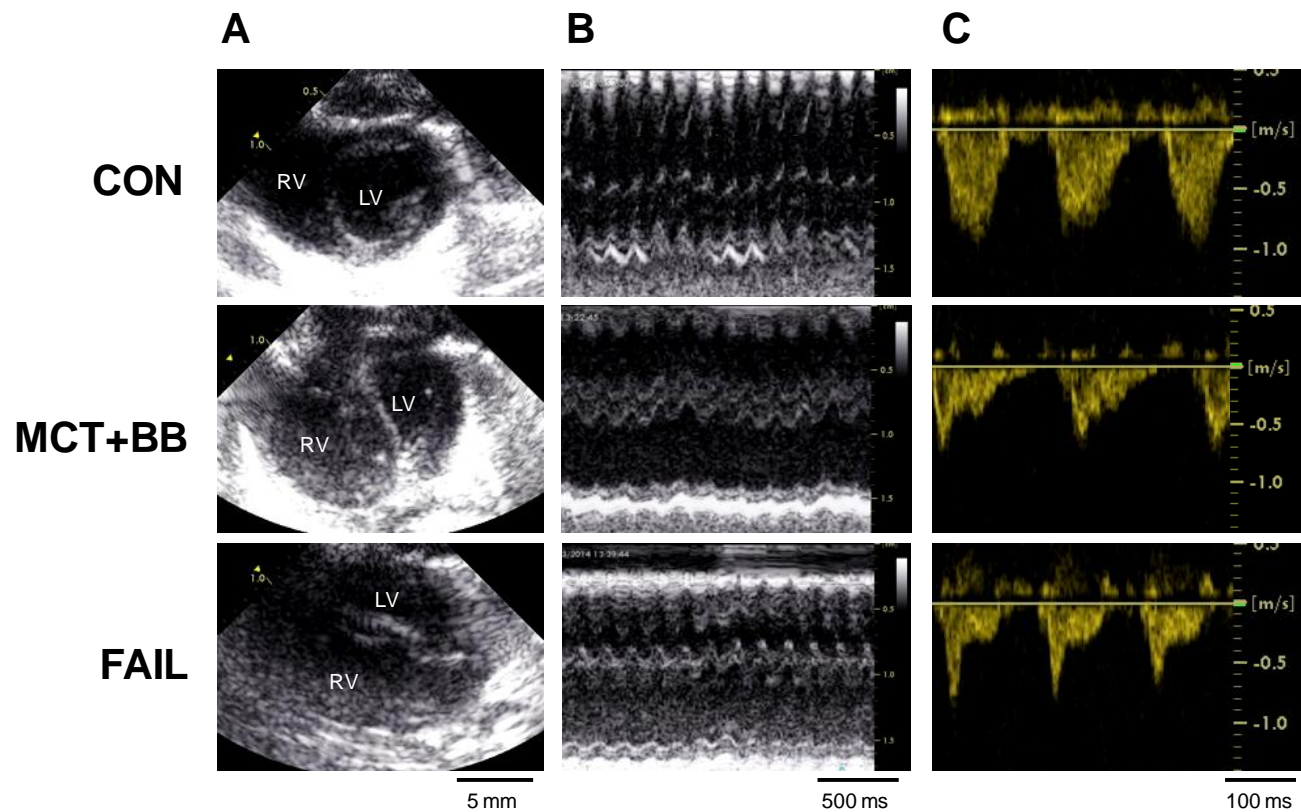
Representative echocardiographic images of a CON, MCT+BB and FAIL heart
